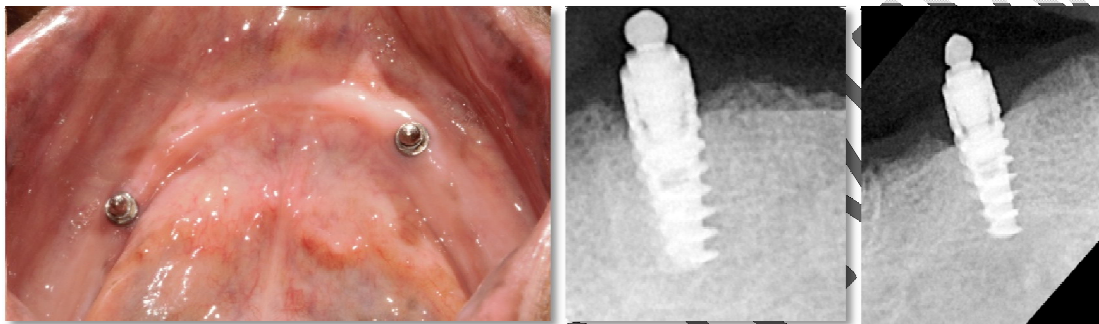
Intraoral and radiographic view of mandibular arch after implant placement
